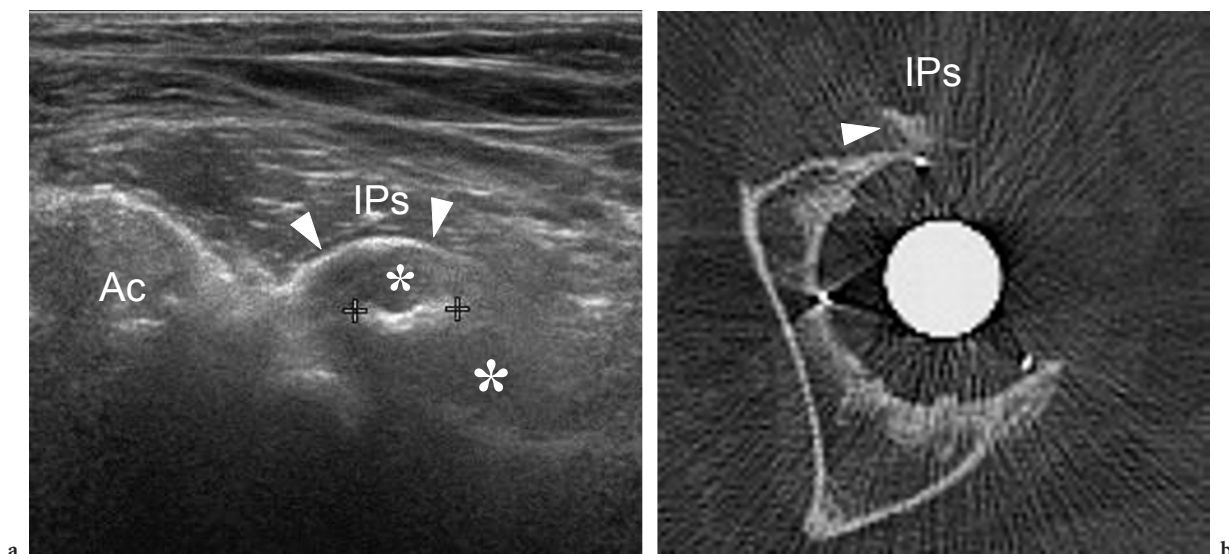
Iliopsoas impingement by an acetabular cup. a Transverse oblique 12–5 MHz US image obtained over the anterior hip shows a beak-shaped hyperechoic projection (*arrowheads*) on the anterior border of the acetabular cup surrounded by an effusion (*asterisks*). *Ac*, acetabulum. *IPs*, iliopsoas muscle. b Correlative transverse CT image demonstrates a hyperdense anterior structure (*arrowhead*) which impinges on the posterior aspect of the iliopsoas muscle (*IPs*), representing cement leakage following the hip replacement procedure
